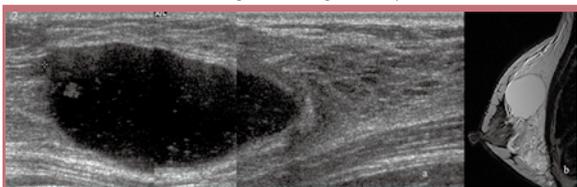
PAAG collections, figure b- MRI examination of same patient shows collections deep to breast parenchyma.
